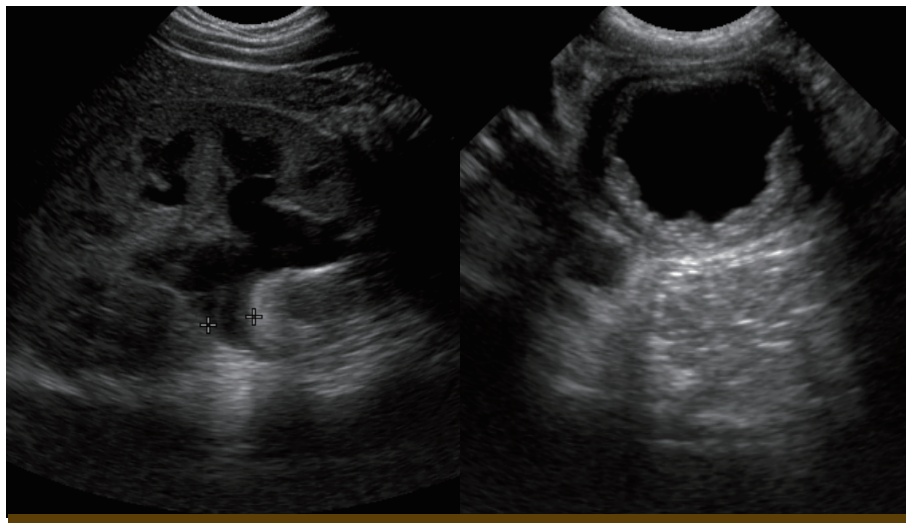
Renal ultrasonography revealed a hydronephrosis and severe thickened bladder wall.
